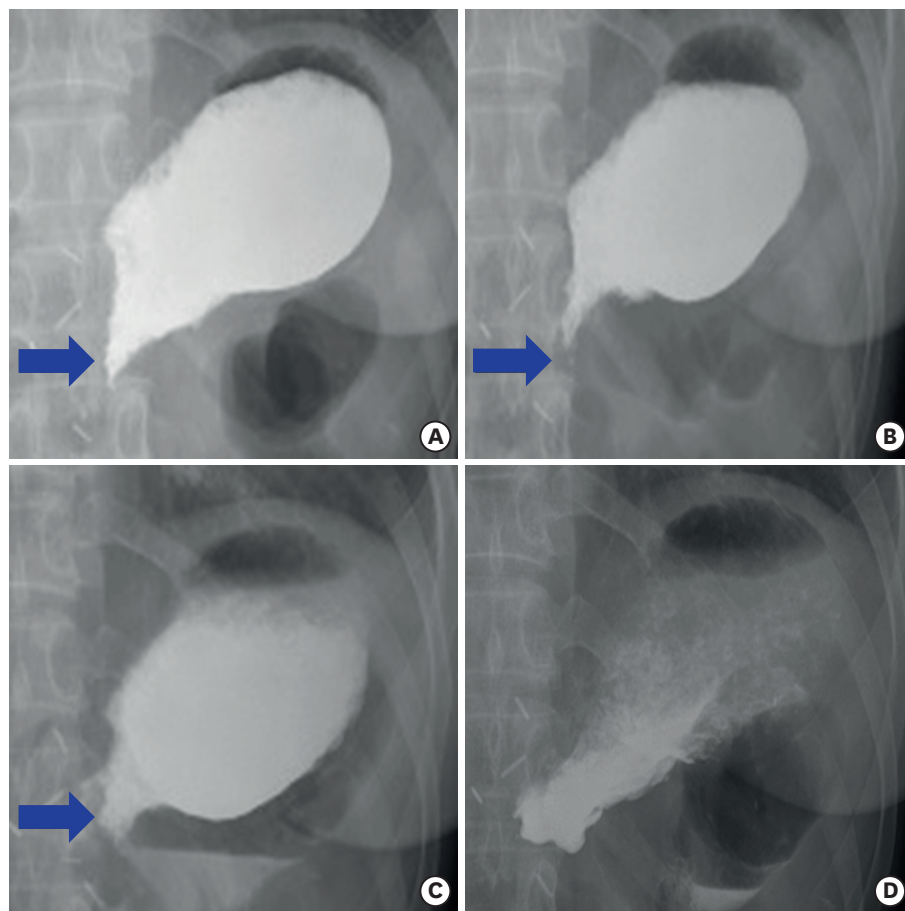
Upper gastrointestinal series and follow-up simple X-ray after botulinum toxin injection. (A) Pre-injection, (B) 2 days post-injection, (C) 4 days post-injection, and (D) 7 days post-injection. The nearly closed pylorus gradually opened (blue arrow), and the residual food in the stomach decreased after botulinum toxin injection. After 1 week, the pylorus widely opened, and the residual food emptied.
